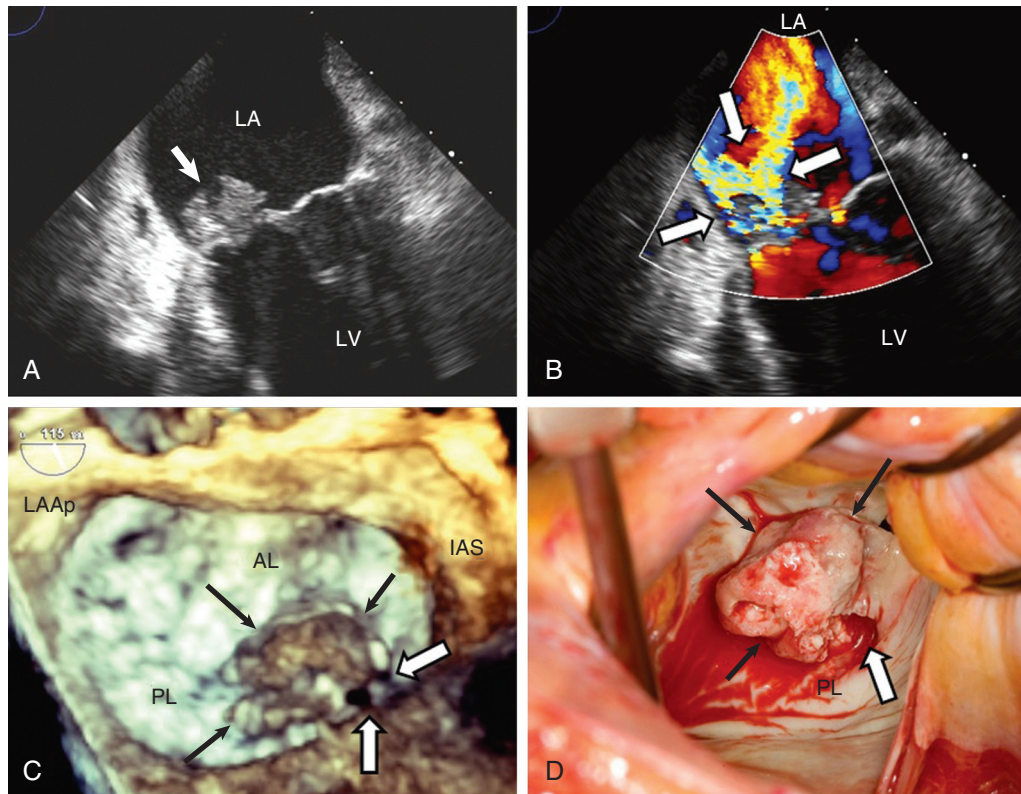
Infective endocarditis involving the mitral valve. A, TEE image shows a large vegetation (arrow) attached to the atrial aspect of the posterior leaflet. B, Color Doppler image demonstrates a complex jet of mitral regurgitation (arrows) coursing through the body of the posterior mitral leaflet and vegetative mass, consistent with leaflet perforation. C, Three-dimensional TEE image of the mitral valve, as viewed from the left atrium (LA). Large vegetations (black arrows) are attached to the medial aspect of the posterior leaflet (PL), with perforation (white arrows) at the margin of the posteromedial commissure. D, Intraoperative visualization of the mitral valve as viewed from the left atriotomy. The large vegetative mass (black arrows) is attached to the posterior leaflet, and the posteromedial perforation (white arrow) is confirmed. AL = anterior leaflet; IAS = interatrial septum; LAAp = left atrial appendage; LV = left ventricle.
